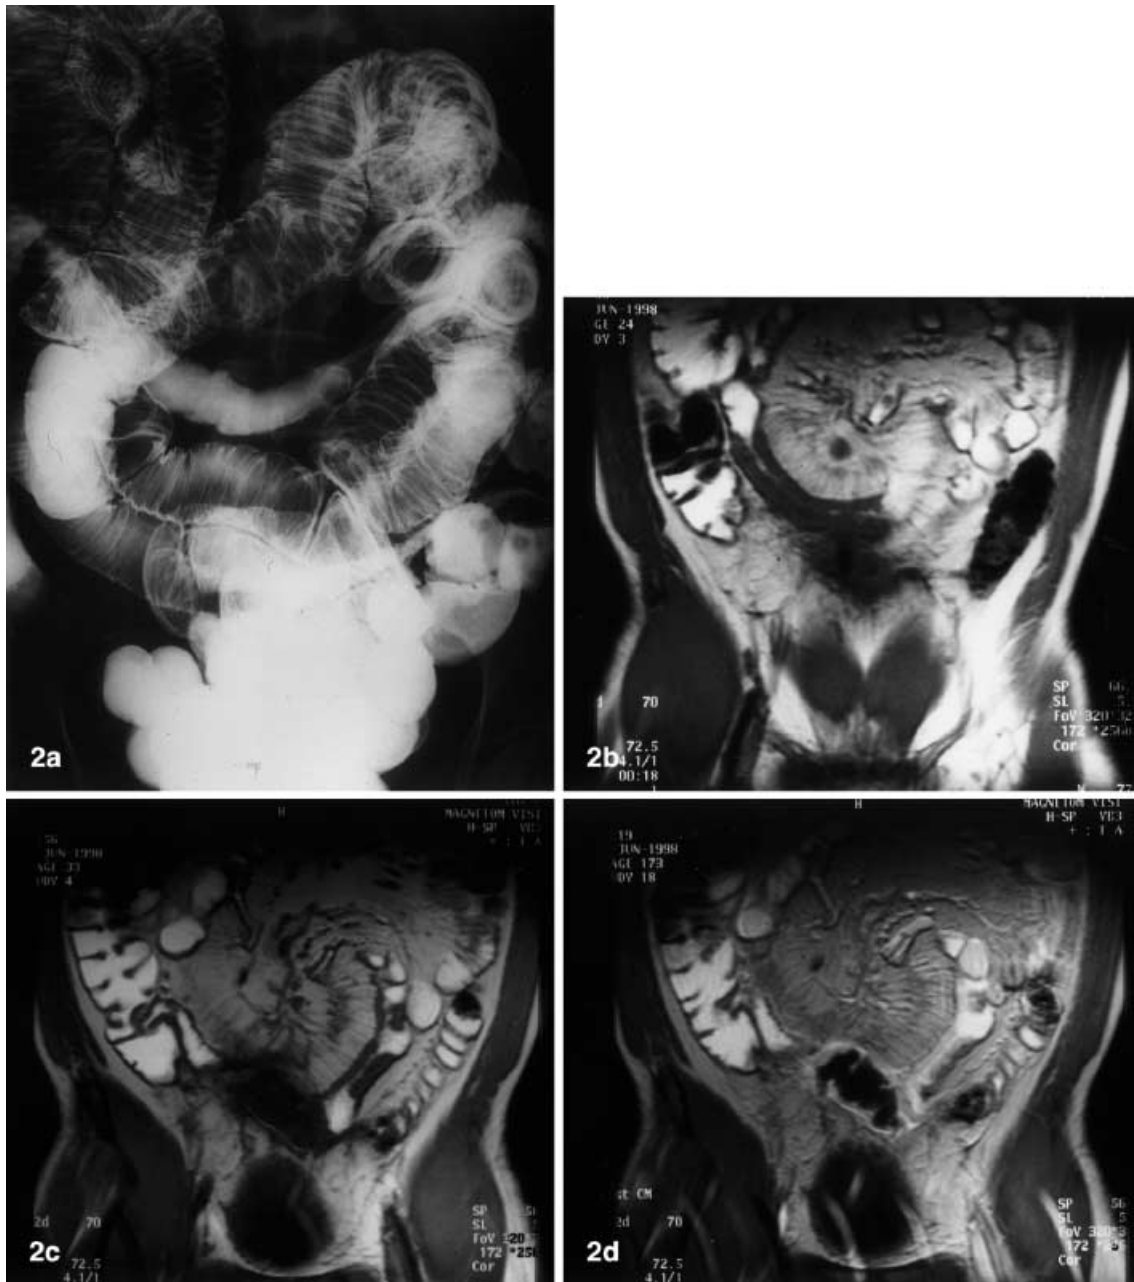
A 38-year-old man with Crohn's disease. a Involvement of a long segment of an ileal loop in the mid-abdomen at enteroclysis. b Coronal, T1-weighted; significant thickening of the bowel wall in the inflamed small bowel loop. c Coronal, T1-weighted MRI 5 mm further ventrally; evidence of a low signal intensity lesion in the mid-abdomen and an additional bowel segment in the left mid-abdomen with thickening of the intestinal wall. This segmental involvement was not detected, even retrospectively, in the findings from enteroclysis. d MRI following intravenous administration of gadolinium DTPA. The pattern of contrast medium uptake clearly indicates the presence of an abscess
